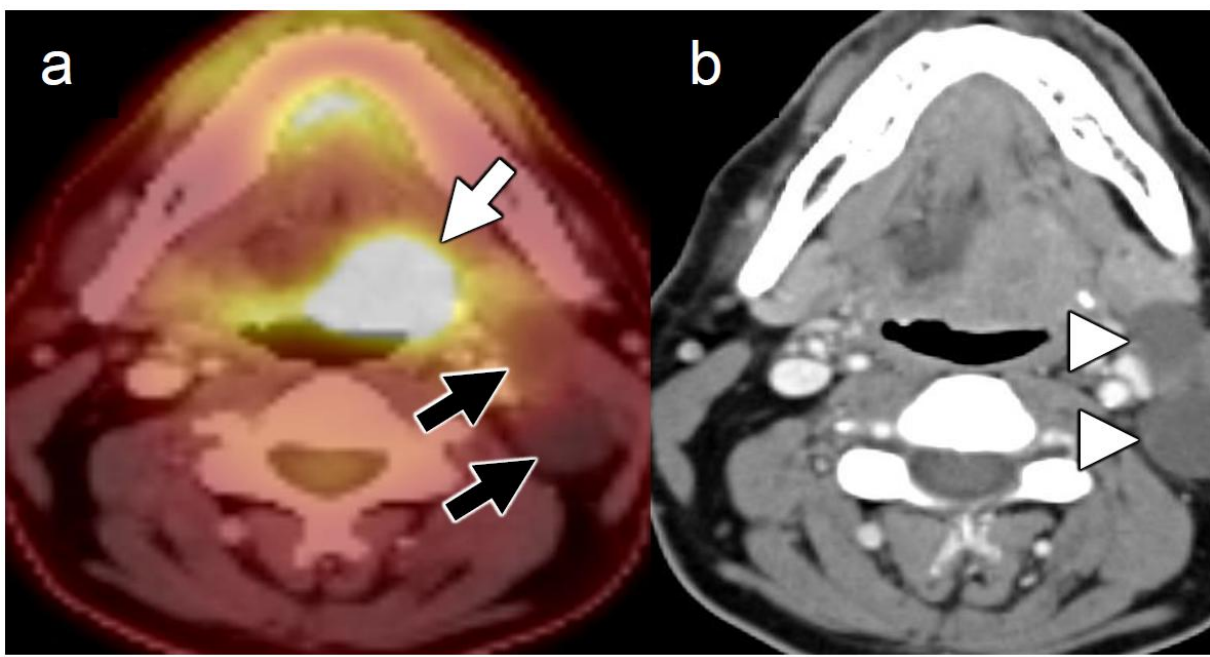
False negative FDG/PET due to necrotic lymph nodes. Fused axial FDG-PET/CT (a) in a patient with left base of tongue squamous cell carcinoma (white arrow) shows two non-FDG avid masses in the left suprahyoid neck (black arrows). Corresponding axial CECT (b) shows these necrotic level II lymph nodes (white arrowheads) to be low density (fluid attenuation). Because of necrosis, these nodes do not have sufficient metabolic activity to register FDG uptake and are an important pitfall in head and neck oncologic imaging.
